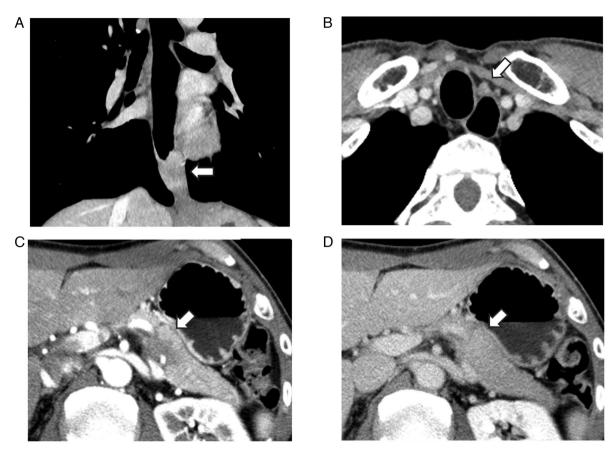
Contrast-enhanced computed tomography scan of the esophageal cancer. (A) Enlarged 106R lymph node, and (B) of the pancreatic tumor (indicated by the arrow), (C) in early phase and (D) in late phase. The pancreatic tumor exhibited gradual enhancement.
